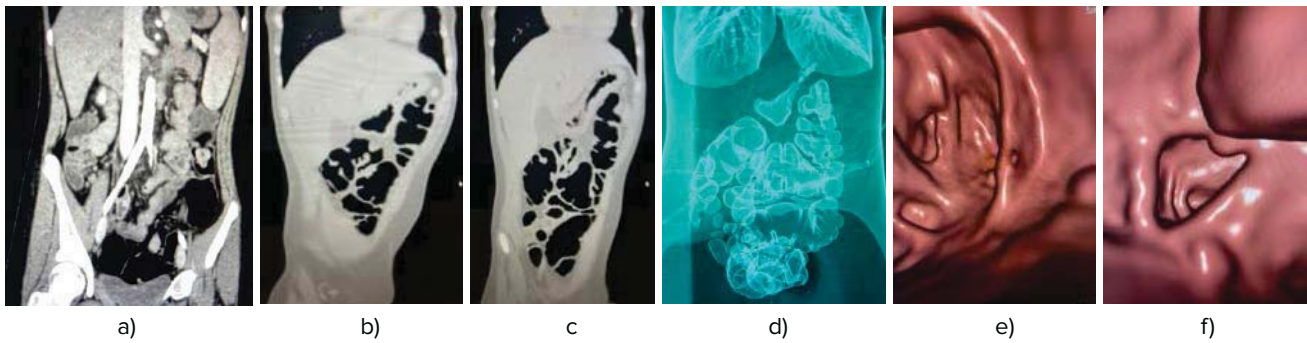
Multispiral computed tomography: numerous polyps in the intestinal lumen. The colon walls are not thickened, but in all sections, there are polyps with a diameter of 3 to 9 mm, located on relatively wide legs, reliably no areas of violation of their integrity were detected: a – coronal slice of the arterial phase of the scan; b, c – use of multi-planar reconstruction and projection of the most intense signal to assess changes in the intestine; d – use of 3D reconstruction; e, f – examination of the intestine in the virtual colonoscopy mode
